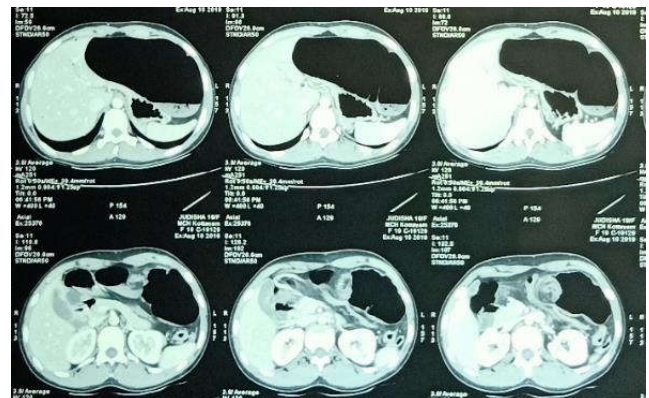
Cross sectional views of the CT film showing hugely dilated and redundant transverse colon
